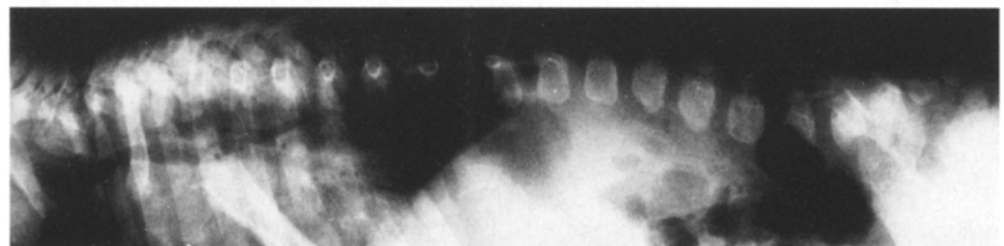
Lateral radiograph of the vertebral column of a 4 1/2-month-old child with G_{M1} -gangliosidosis. The lumbar vertebrae are irregular and the intervertebral disks are wide
